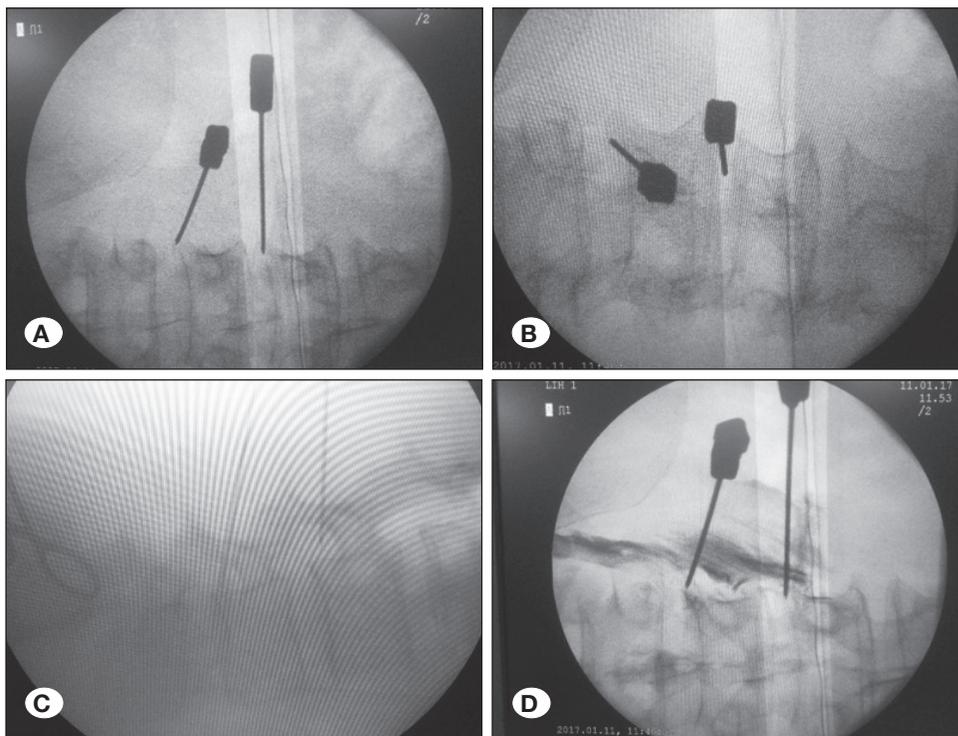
Fluoroscopic control radiographies at PA (A), oblique (B), lateral (D) and post dye injection, which showed off the root (D).
